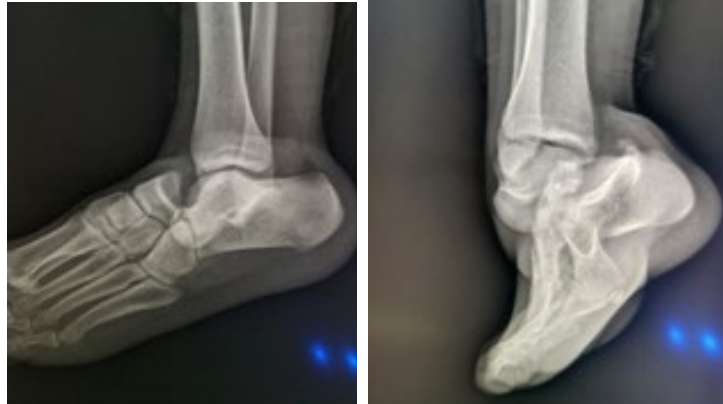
X-ray of the ankle showing a medial subtalar dislocation
